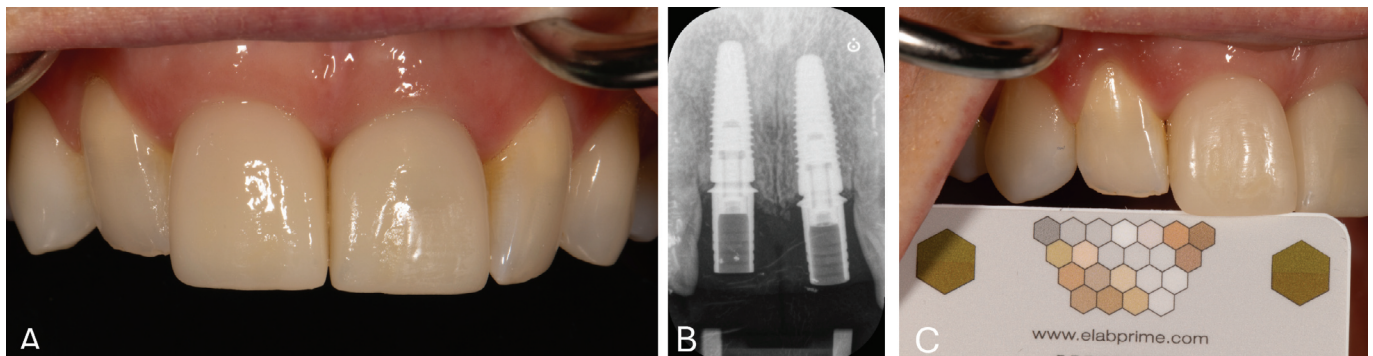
(A) Two maxillary central incisors lost to dental trauma with provisional implant restorations in situ ready for permanent restoration fabrication. (B) Periapical radiograph of provisional restorations and implants. (Surgical work courtesy of Dr Mark McLaughlin, periodontist.) (C) Photograph of target tooth to be matched (maxillary lateral incisor) with the presence of a calibrated grey card.
